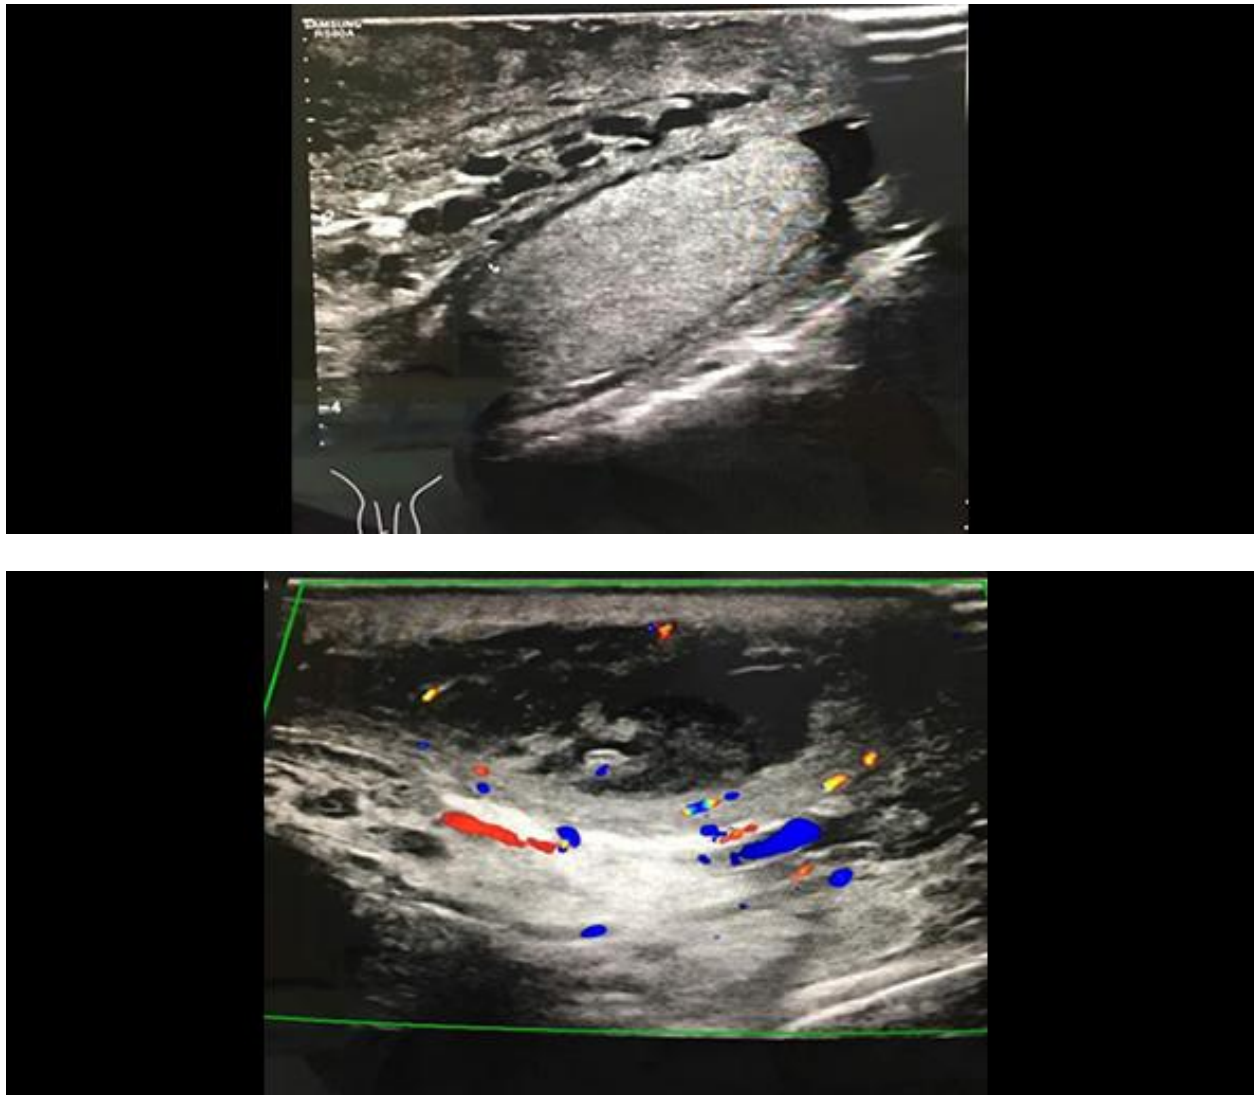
(above): Sagittal view ultrasound of left testis showed normal homogenous parenchymal echotexture. There was no obvious focal lesion seen with the testicular parenchyma. However, the left scrotal sac was edematous and thickened. (Below): Ultrasound doppler scrotum revealed engorged, dilated and slow flow of pampiniform plexus of left testis. There are some areas of none or sluggish flow suggestive of thrombosis. There was a focal dilated vein in the most inferior part of left scrotal sac.
